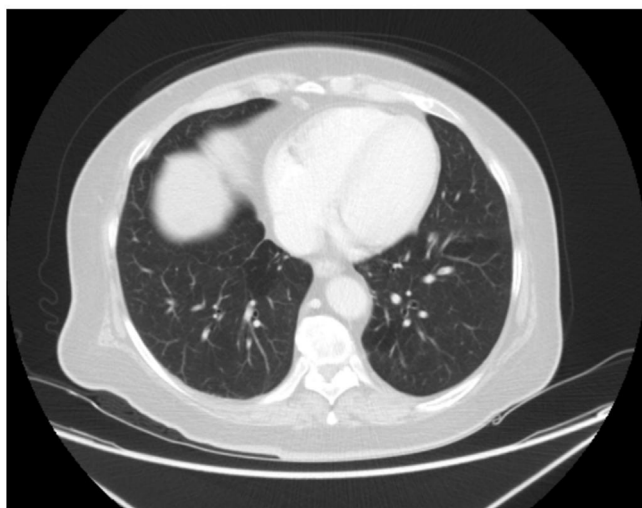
After 10 months on control CT examination, bronchiectasis appearance could not be seen.
